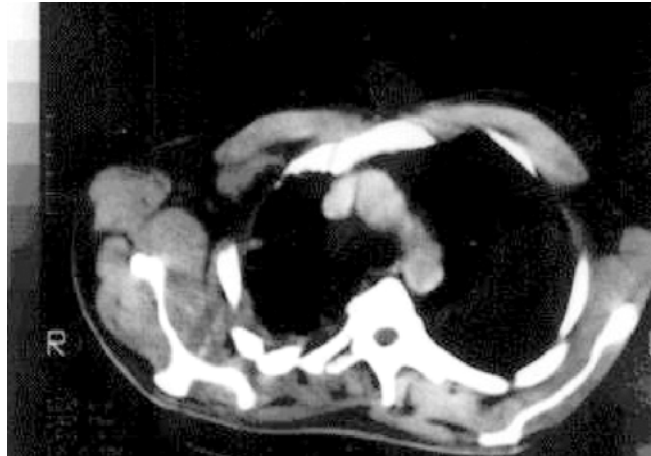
Transverse cut of CT chest of the same patient with partial response.
